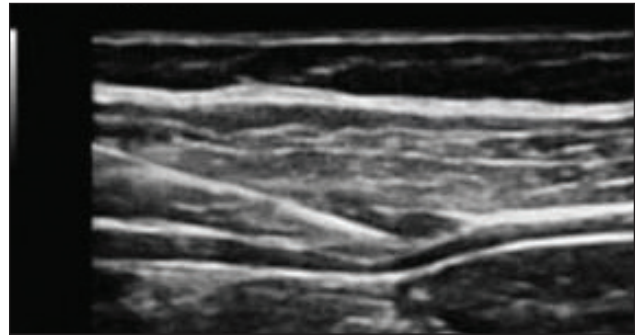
Image of transversus abdominis space and needle in ultrasonography
